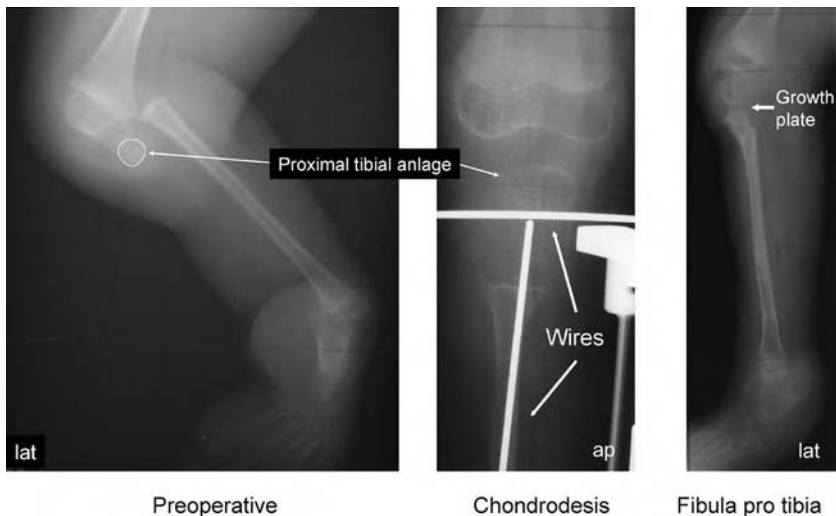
X-ray series of a six-year-old girl with tibia type IIIb. Left picture shows the situation before surgery. Middle picture shows the fixation of the tibial anlage and fibular head by an axial fibular wire and a transverse wire through the tibial anlage. Right picture shows the situation after surgery and removal of the ring fixator. Note the open growth plate of the former fibula head after the osteo-chondro-synthesis between fibular head and tibial anlage.
